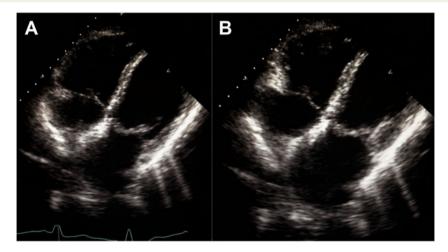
Trans-thoracic echocardiography images. Modified apical four-chamber views showing (A) end-diastolic and (B) end-systolic frames demonstrating both LV and RV apical ballooning.
